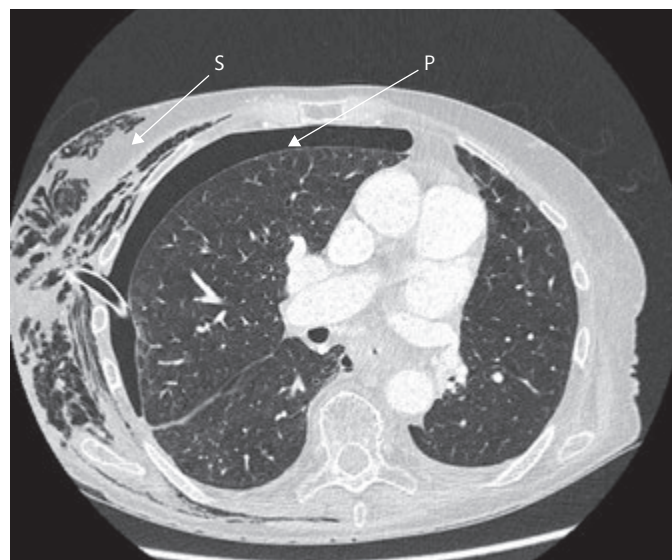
CT showing a secondary pneumothorax (P) with subcutaneous air (S) (surgical emphysema). A chest tube is seen entering the chest cavity from in between the ribs.
